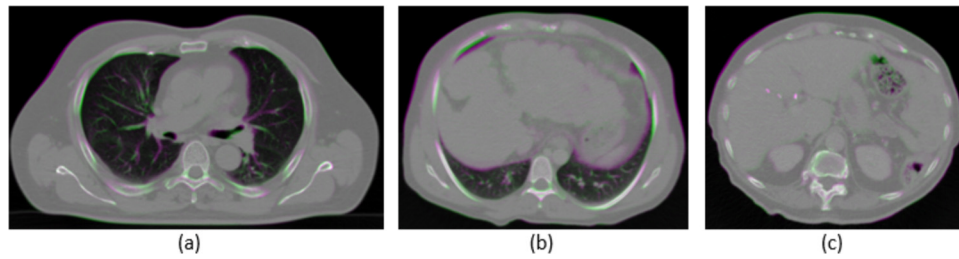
Demonstration of geometric distortion application with the overlay of undistorted CT (green) and distorted CT (purple) images, for (a) lung Patient 3 (b) liver Patient 3, and (c) pancreas Patient 2. Areas of agreement are depicted in gray scale.
